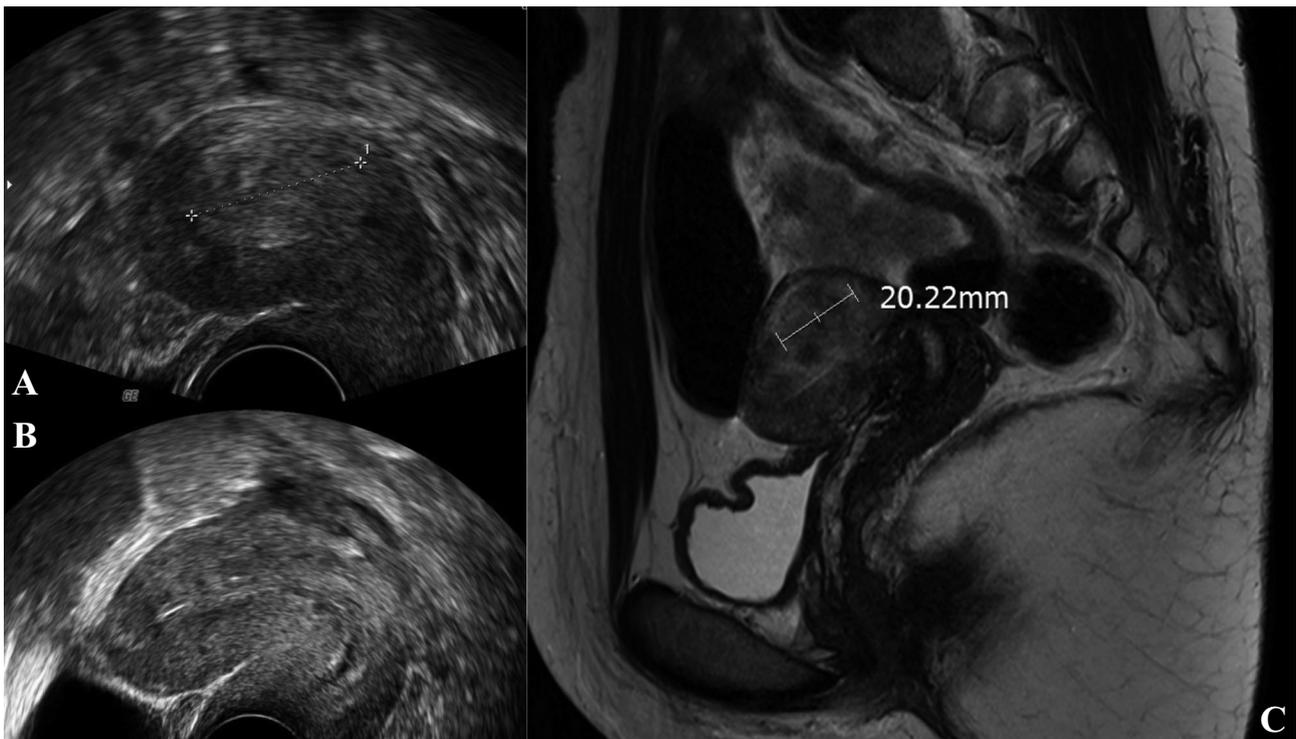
A) Ultrasonography shows sagittal view of the uterus with heterogeneous echoic mass in the posterior body. B) A circa 2-cm width ill-defined heterogeneous hyperintense lesion on T2WI with asymmetric myometrial invasion in posterior body of uterus; strong peripheral enhancing with central hypointensity. C) Postoperative ultrasonographic image shows clear endometrial lining without any myometrial defect.
